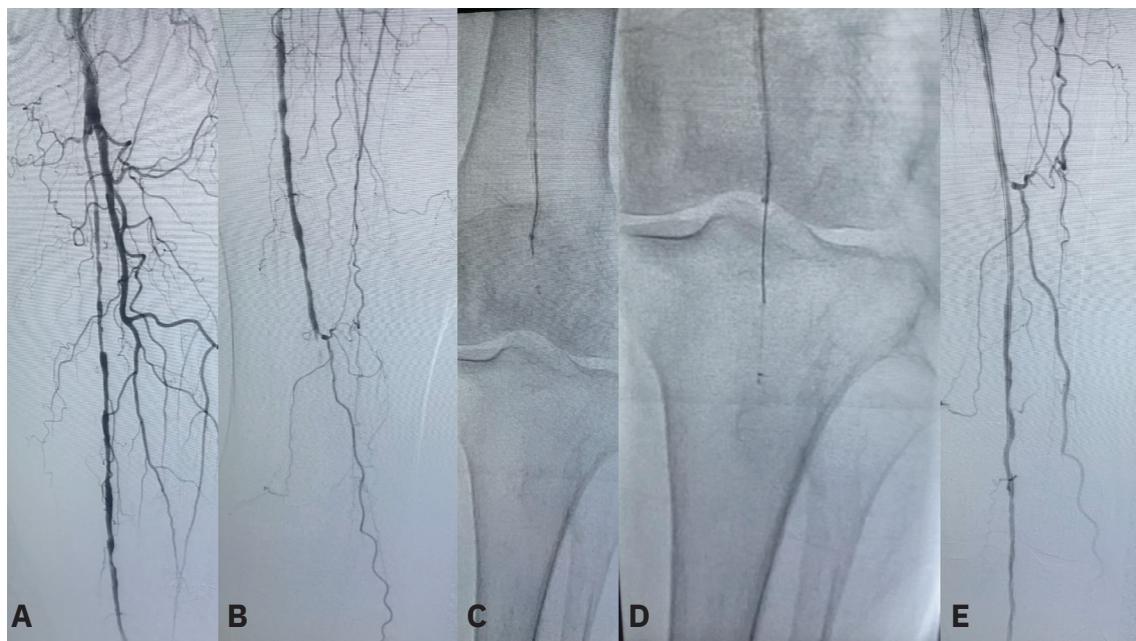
A 75-year-old woman with rest pain and a nonhealing left great toe wound was referred for lower extremity angiography. (A) Baseline angiography demonstrated a diffusely diseased left superficial femoral artery. (B) The mid popliteal artery was totally occluded with a large collateral near the stump of the ongoing vessel. (C) The Crosser iQ™ Ultrasonic CTO Device (Becton, Dickinson and Company) was able to navigate into the ongoing cap of the occluded artery. (D) Magnified view demonstrates the luminal crossing of the device across the distal popliteal artery. (E) After initial angioplasty, there was excellent luminal gain and minimal dissection. The patient was subsequently treated with further adjunctive therapies (not shown).
